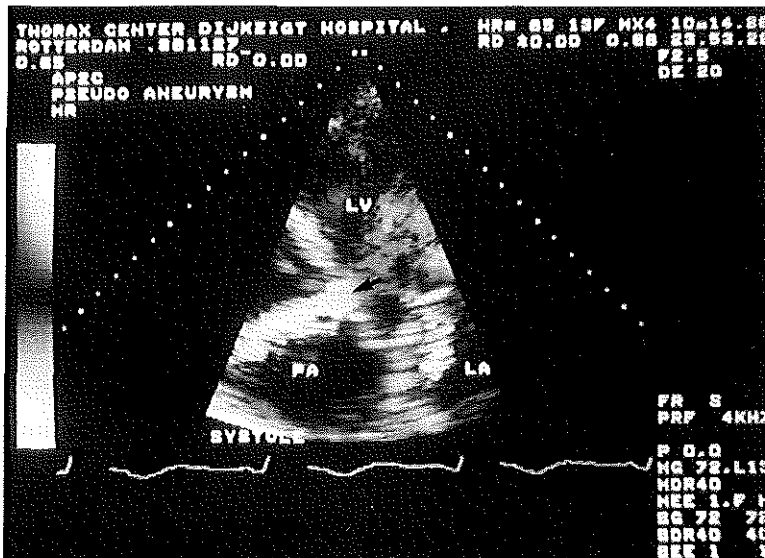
Blood flow through the defect from the left ventricle (*LV*) into the pseudoaneurysm in the same patient as shown in Figure 4, visualized with the color Doppler flow imaging system in systole (see arrow).
